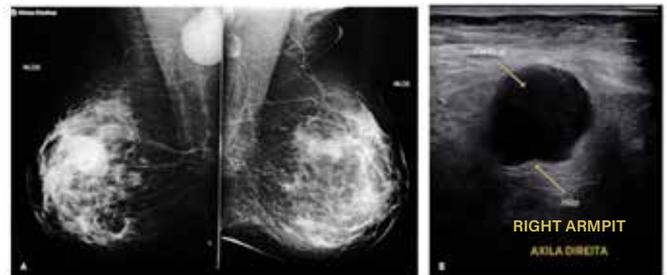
A. Mammogram showing hypertrophic lymph node in the right axilla. B. Ultrasonography. Entirely hypoechoic lymph node, with hilum pushed back to the periphery, associated with secondary metastatic involvement, in the right axilla, due to breast cancer.
